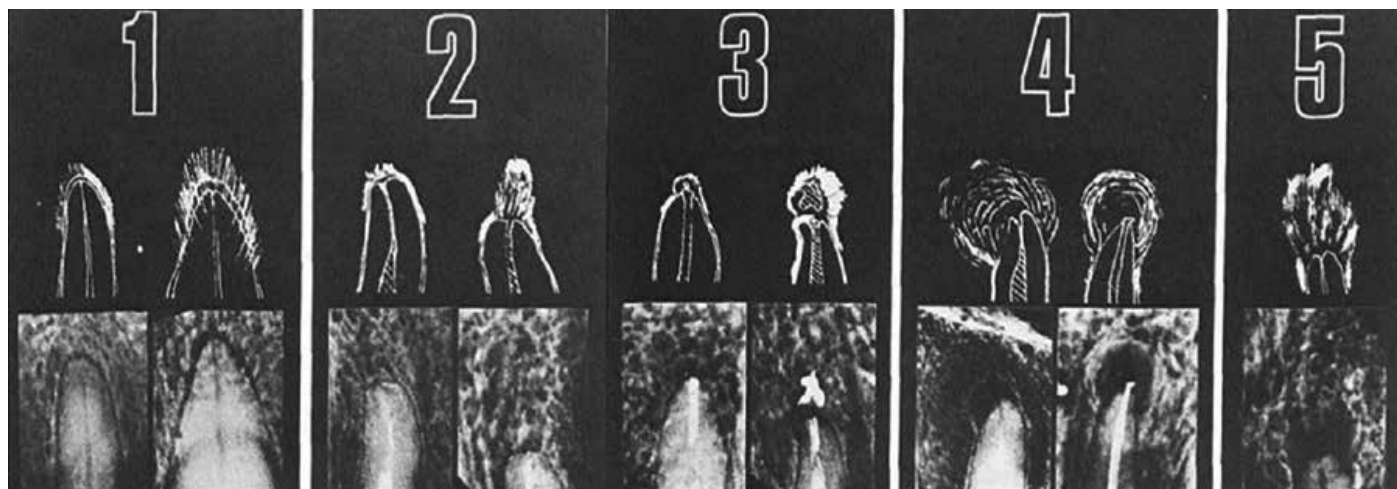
Periapical index scoring system [Ørstavik et al. (22)]
